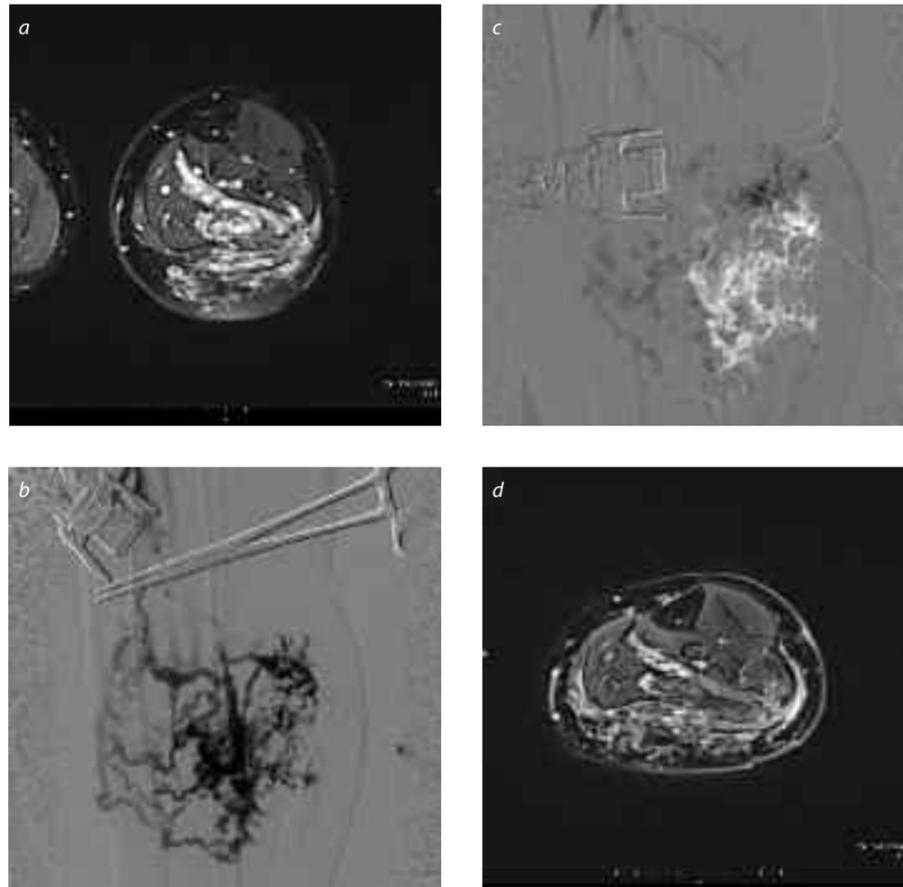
Polidocanol foam sclerotherapy for a painful lower leg VM. (a) Fat-suppressed T2-weighted MR image showing a varicose type VM. (b) Digital subtraction venogram obtained during injection of iodinated contrast medium via a direct puncture needle showing opacification of the VM. A tourniquet was applied to the limb. (c) Digital subtraction venogram obtained during injection of sclerosing foam showing negative contrast medium in the VM. (d) Pain disappeared and the VM shrunk 5 months after sclerotherapy.
